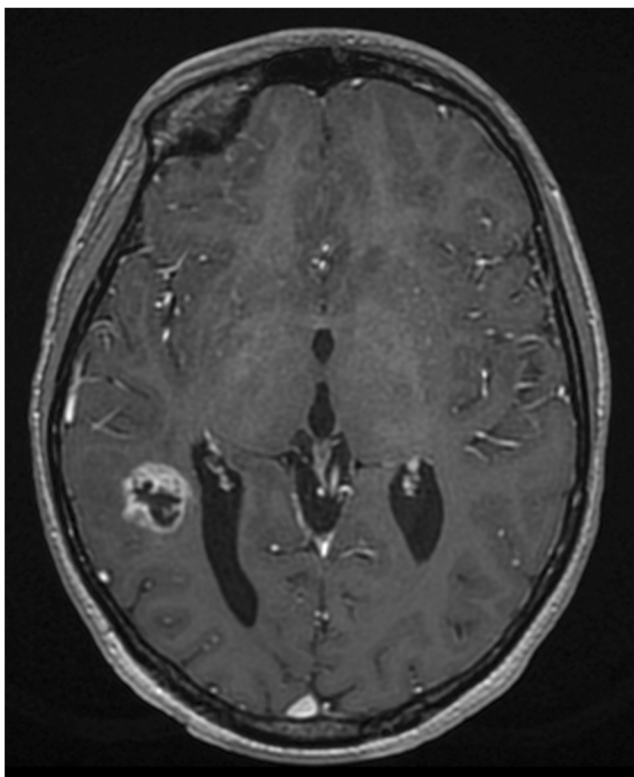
MRI showing a secondary glioblastoma multiforme in the right posterior temporal lobe in a 17-year-old male 12 years after a diagnosis of an average-risk medulloblastoma
